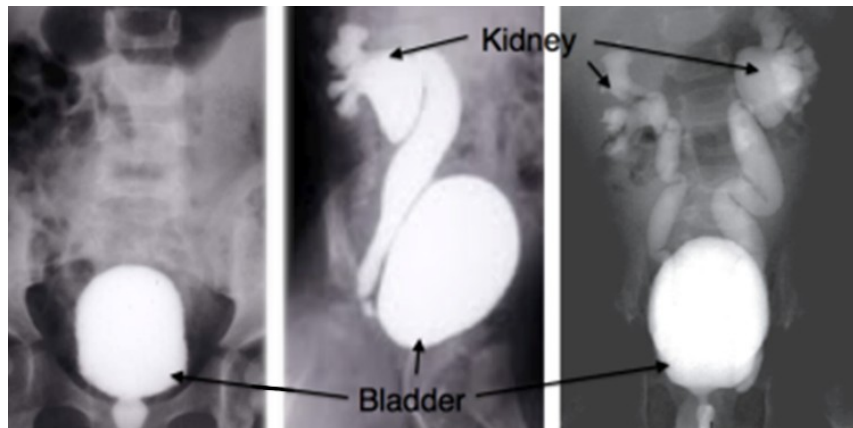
X-ray images of contrast agent in a patient (*left*) with no VUR (full bladder), and (*middle and right*) with severe Grade V VUR (side and front views, respectively; bladder, ureters and kidneys filled).
